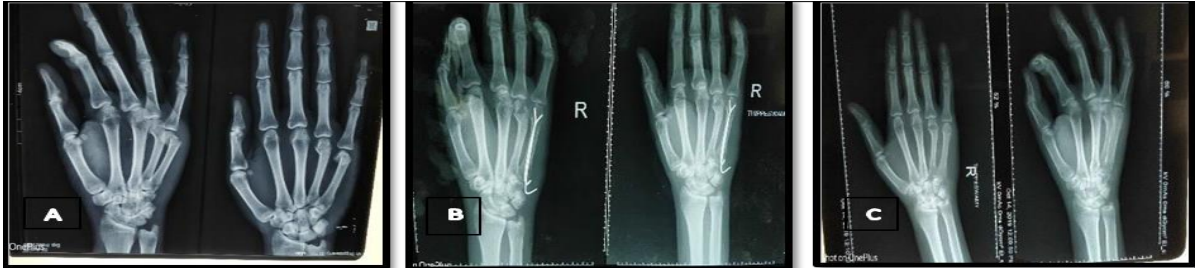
(A) Pre-operative x-ray with angulation at 5th metacarpal neck, (B) angulation corrected after k wire insertion by antegrade manner, (C) complete union without any angulation
